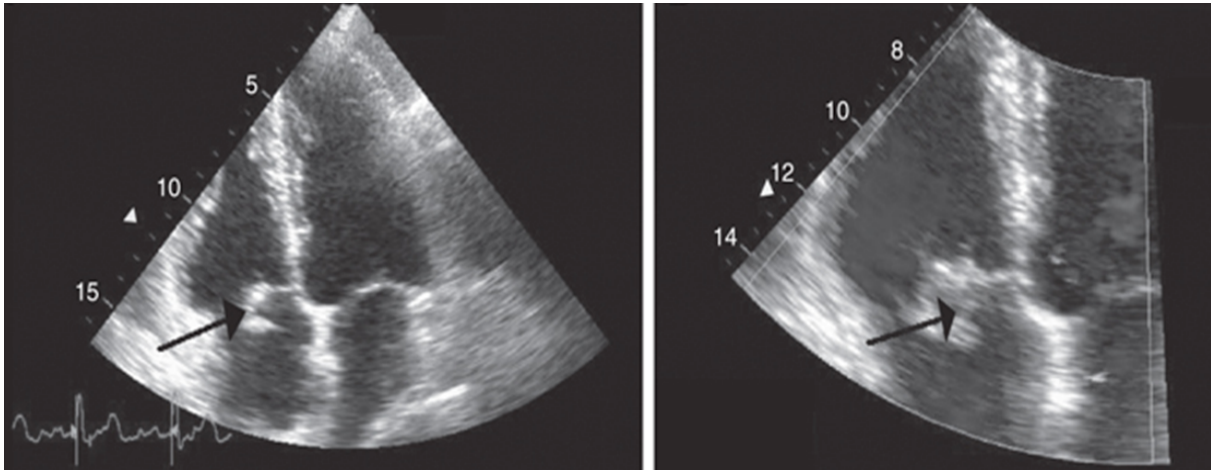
Trans-oesophageal cardiac ultrasound showing vegetation on one of the cusps of the tricuspid valve (black arrow).
